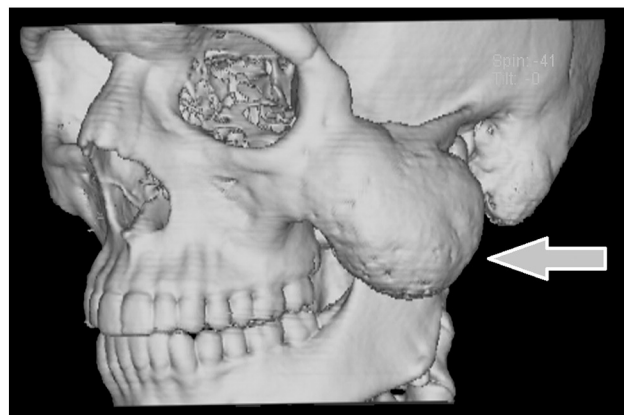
CT 3D reconstruction shows the extent of the lesion (arrow).
